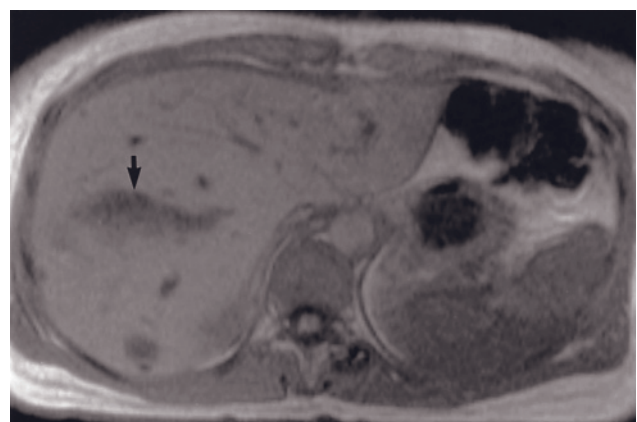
Hepatic hemorrhage after trauma. T2-weighted fat-suppressed ETSE (a), SGE (b), and 45-s postgadolinium SGE (c) images. There are two hematomas in the liver parenchyma that demonstrate heterogeneous moderate high signal on T2-weighted
